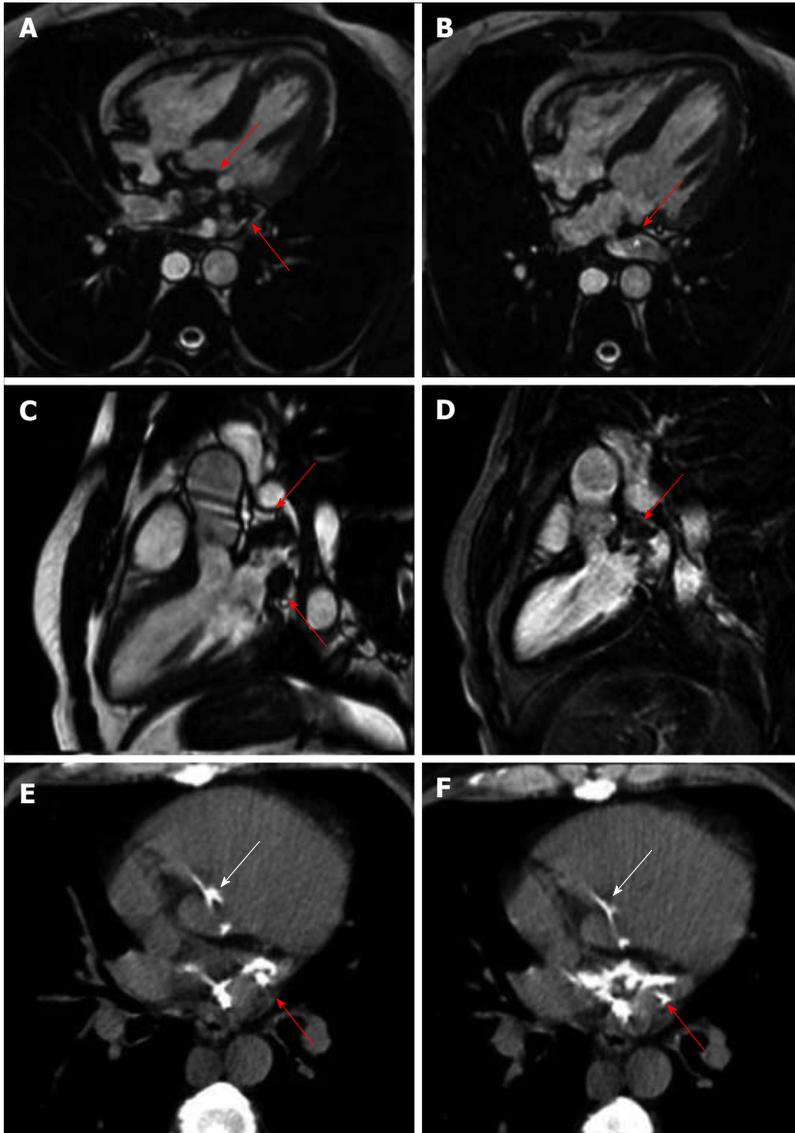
Photograph. A-D: Cardiac magnetic resonance showed hypointense areas located in left atrium and atrio-ventricular plane (red arrows); B: Partial obstruction of superior pulmonary vein; E and F: Cardiac computed tomography showed the presence of a mass suggestive of calcium in left atrium (red arrows), atrioventricular groove and aortic left ventricular outflow (white arrows).
